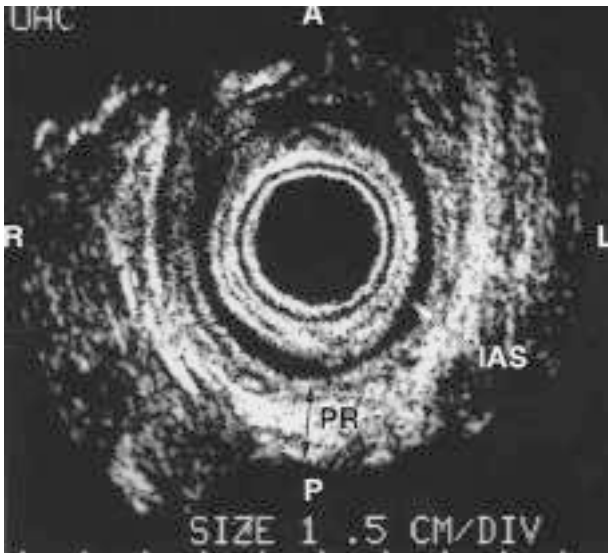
Two-dimensional endoanal ultrasound view of the U-shaped puborectalis muscle (PR). IAS internal anal sphincter.
